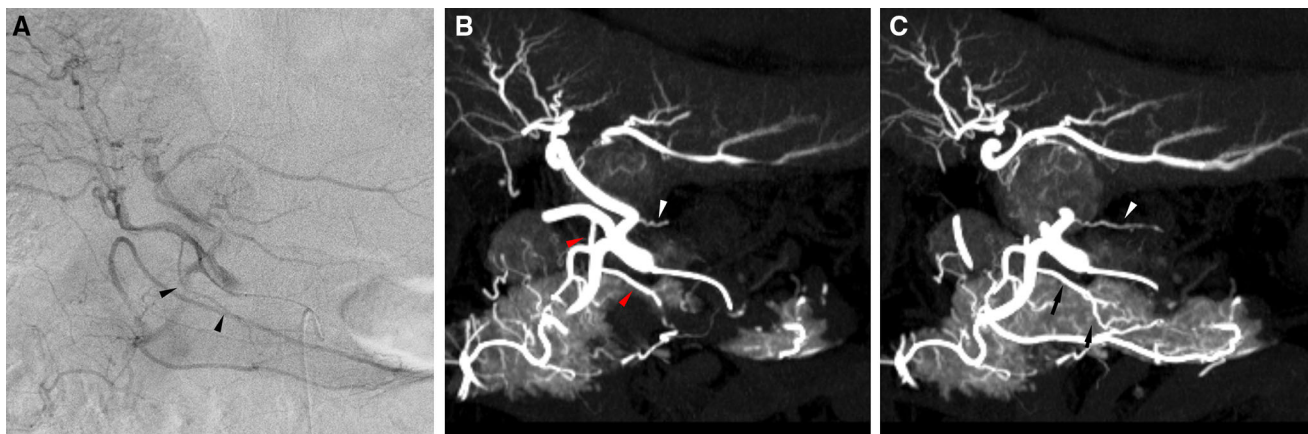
Images of the dorsal pancreatic artery in a 72-year-old man with a normal liver. A A branch arising from the right hepatic artery (*black arrowheads*) was identified on the common hepatic arteriogram, although the vascular territory was uncertain. Another extrahepatic branch was missed during the first blind interpretation. B, C Coronal CT hepatic angiography (CTHA) images (maximum
